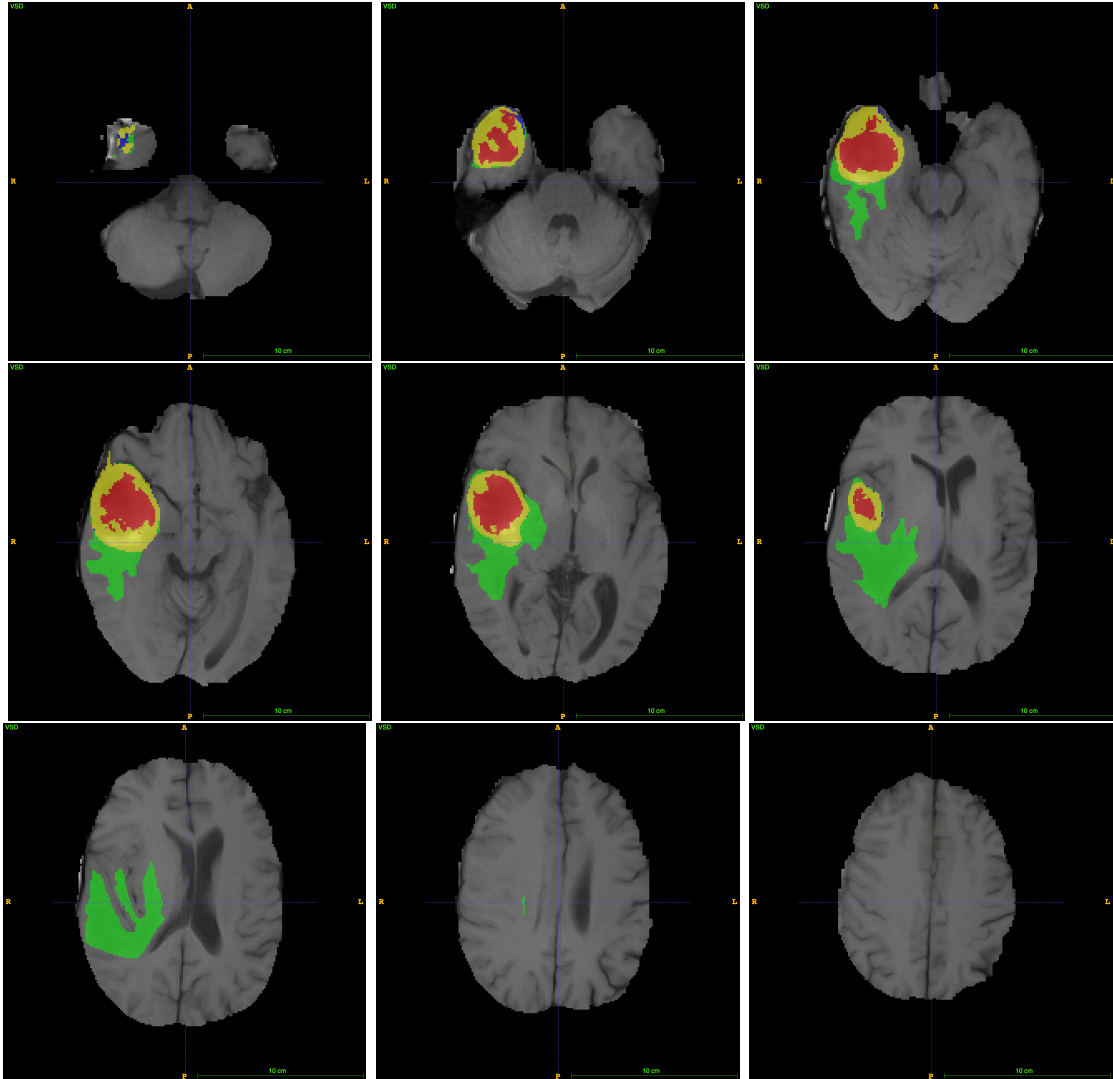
Axial plane slices of a T1 MRI scan annotated by the expert labelling. The slices were taken from patient 1, using $z \in \{49, 59, 69, 79, 89, 99, 109, 119, 129\}$. The enhancing tumour region is in yellow, the non-enhancing tumour in blue, the edema in green and the necrotic core in red, corresponding to classes 4, 3, 2 and 1 respectively.
